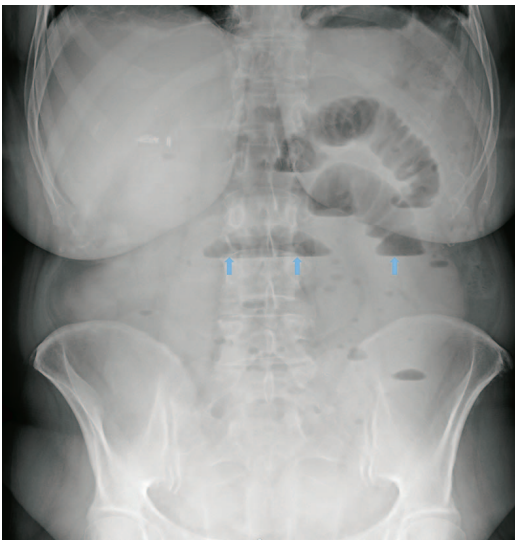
X-ray of the native abdomen
